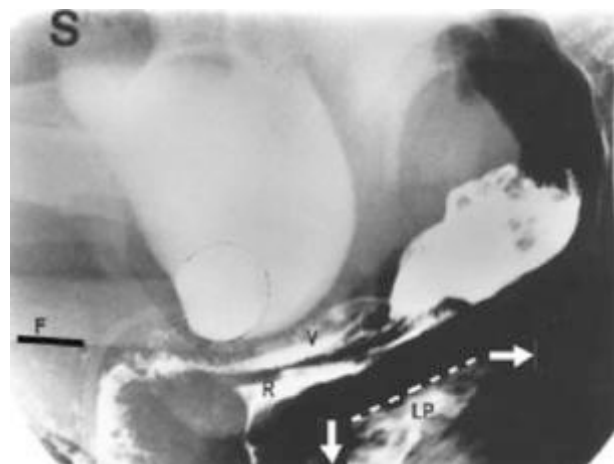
Straining X-ray, sitting position. With reference to “F”, lower border of femur, bladder, proximal vagina (V) and rectum (R) are stretched backwards and downwards during straining. Note downward angulation of levator plate (LP).
